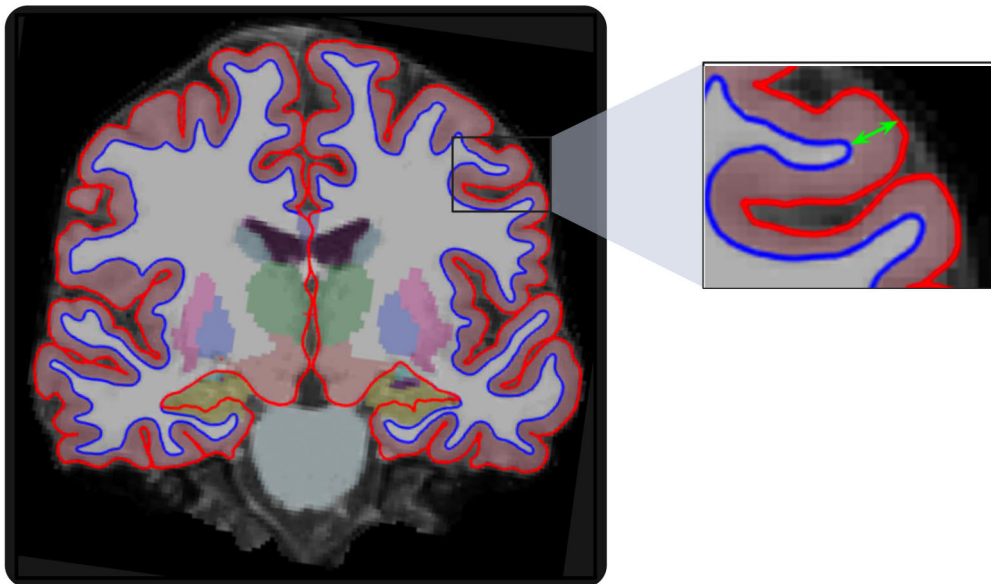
Demonstration of a cortical thickness measure (green arrow) acquired from a segmented T1-weighted MRI sequence. Created by the author with BioRender.com.
